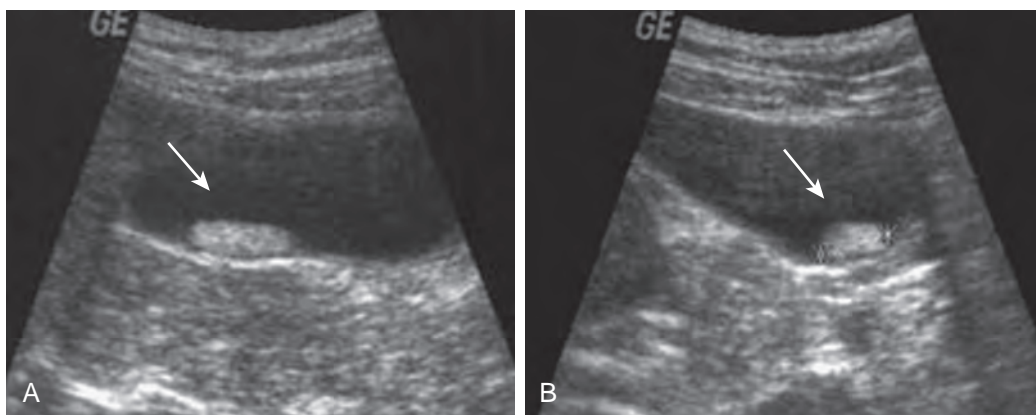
Tumefactive sludge: sonography. A. In the supine position, there is an echogenic nonshadowing focus (arrow) in the dependent portion of the gallbladder lumen. There is no posterior acoustic shadowing. B. In the upright position, the sludge ball moved into the gallbladder fundus (arrow).
